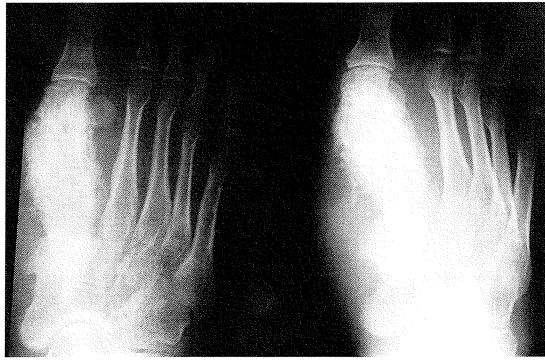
Frontal (left) and oblique (right) radiographs of the right foot.
